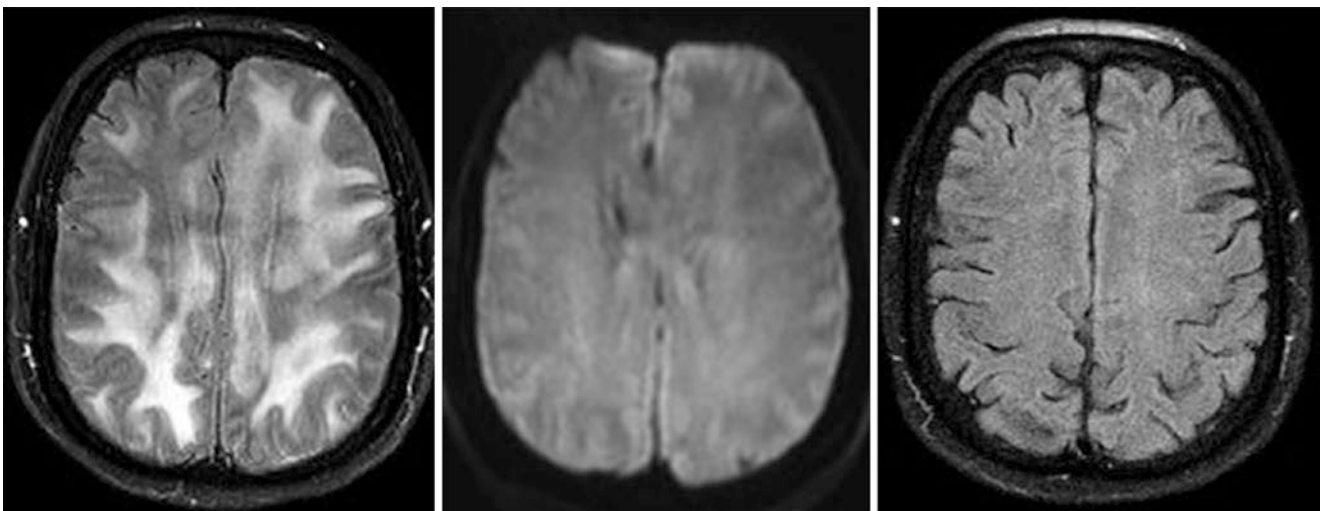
Comparison case of acute disseminated encephalomyelitis (ADEM). A 58-year-old underwent a 1.5 T MRI, which demonstrated confluent abnormalities throughout the deep PVWM on axial FLAIR (*left*), but did not show reduced diffusivity on DWI (*middle*). Six months later, the abnormalities had entirely resolved on FLAIR (*right*)
